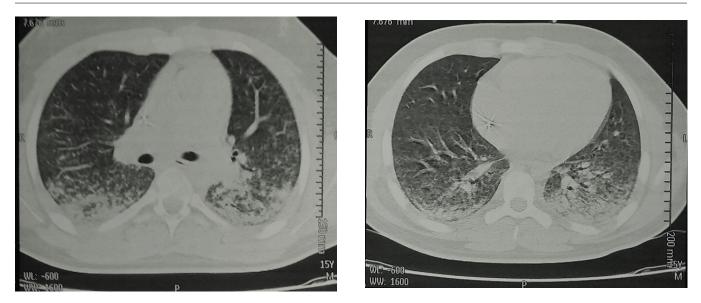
Chest computed tomography on admission: ground glass infiltrates with consolidation areas predominantly in lower lobes, associated with diffuse tree-in-bud infiltrate and centrilobular nodules.
